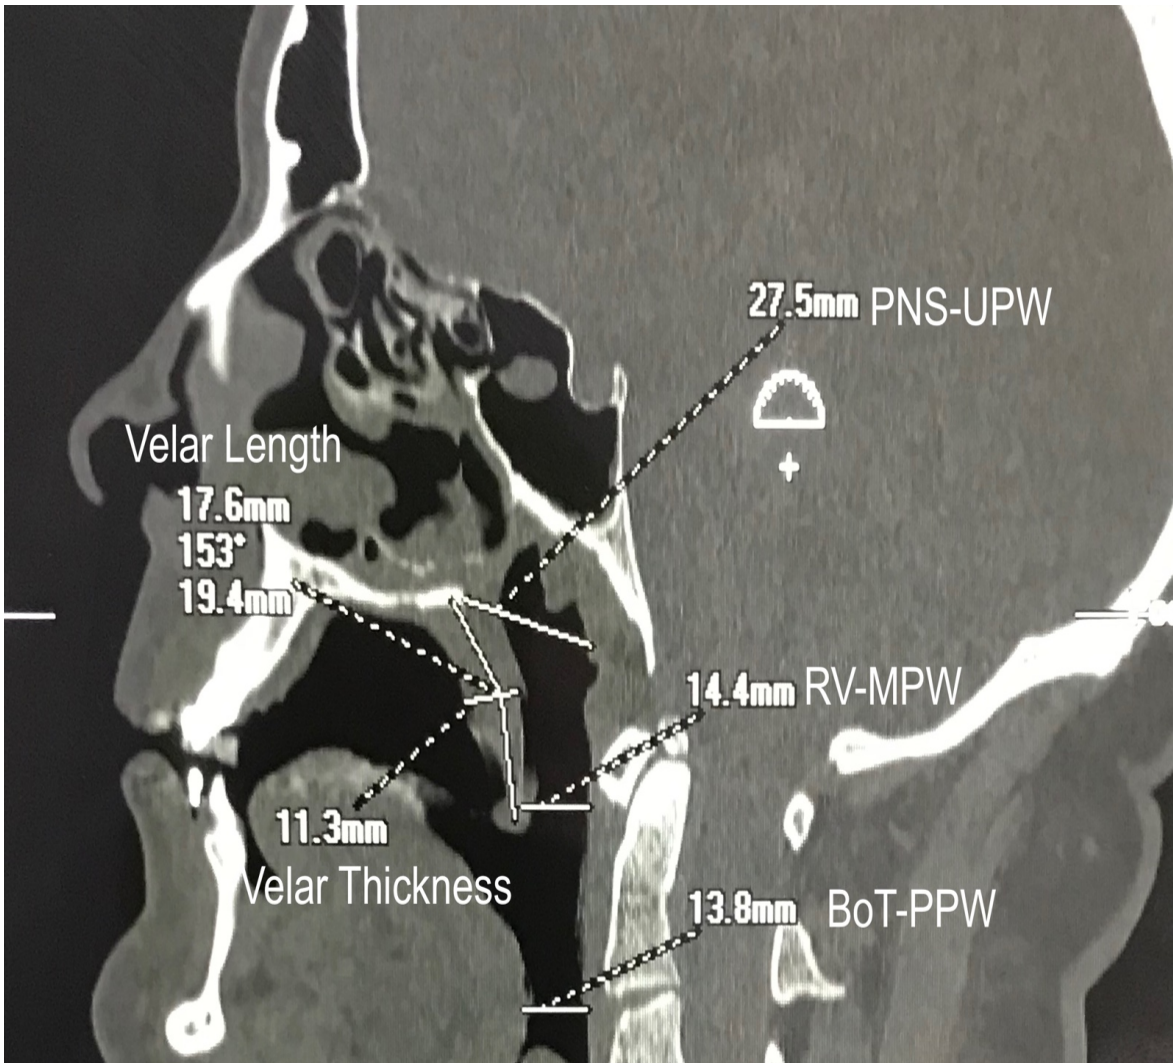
Linear distances assessed on sagittal reconstruction of CT scan
